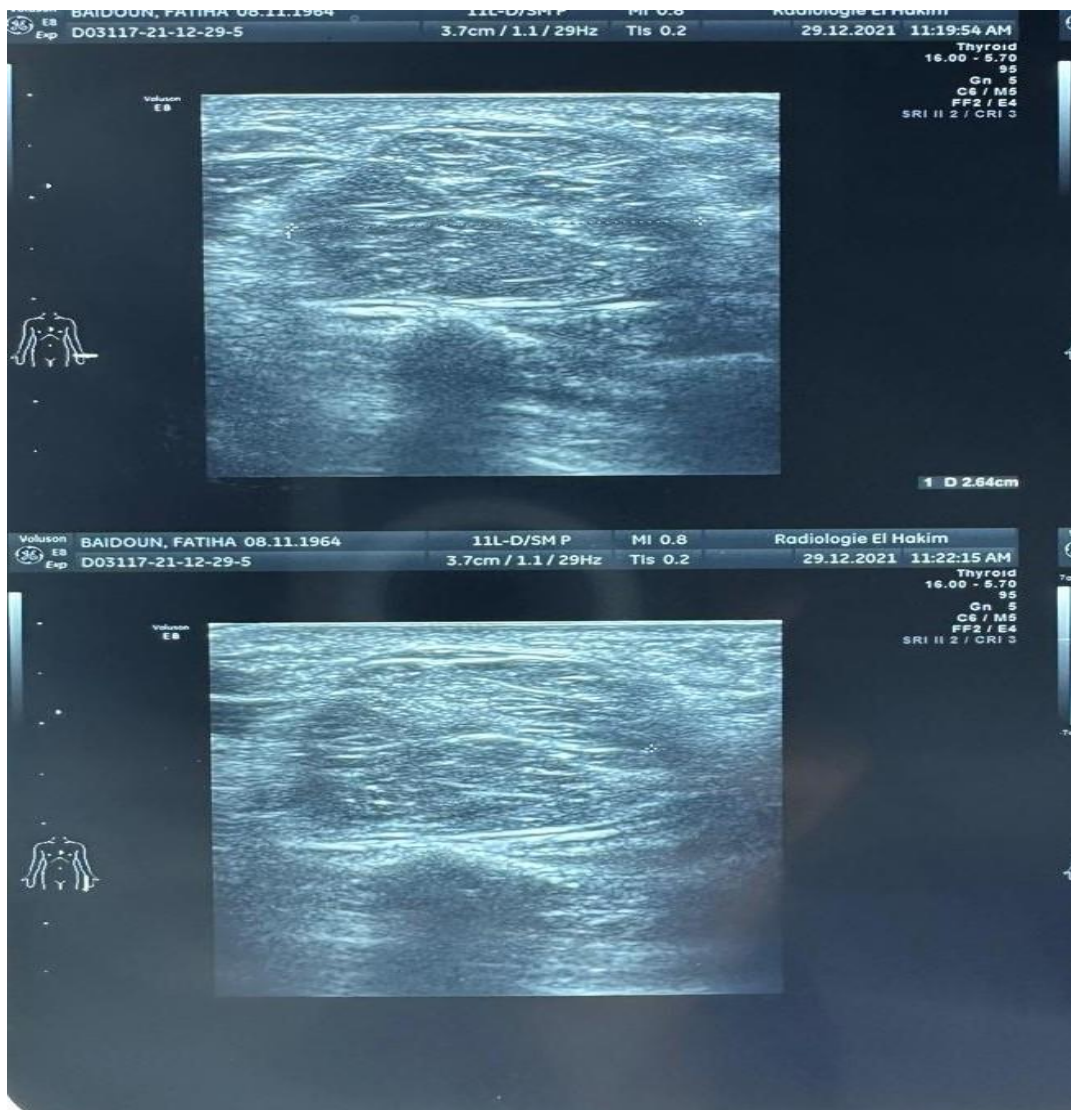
Appearance of the mass on ultrasound
